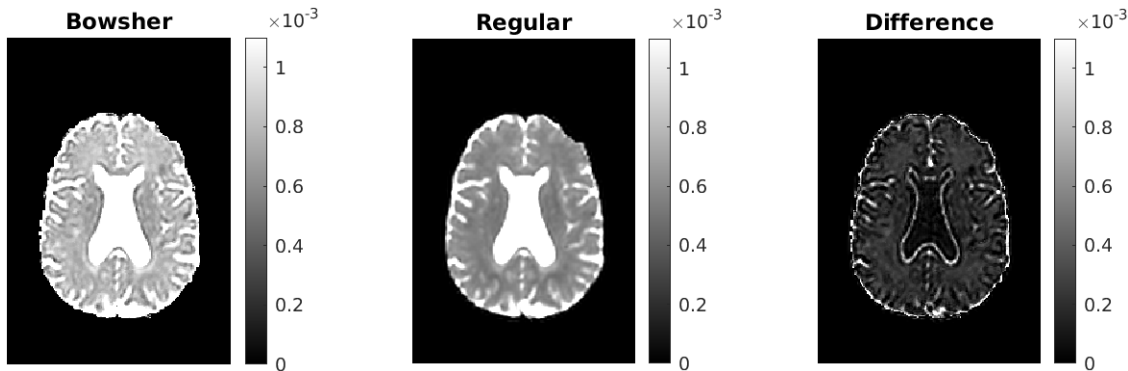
MD-maps of a slice in a Bowsher prior reconstructed DWI along with the regular DWI before the reconstruction. Furthest to the right, a difference image can be seen which shows the subtraction of the Regular from Bowsher.
